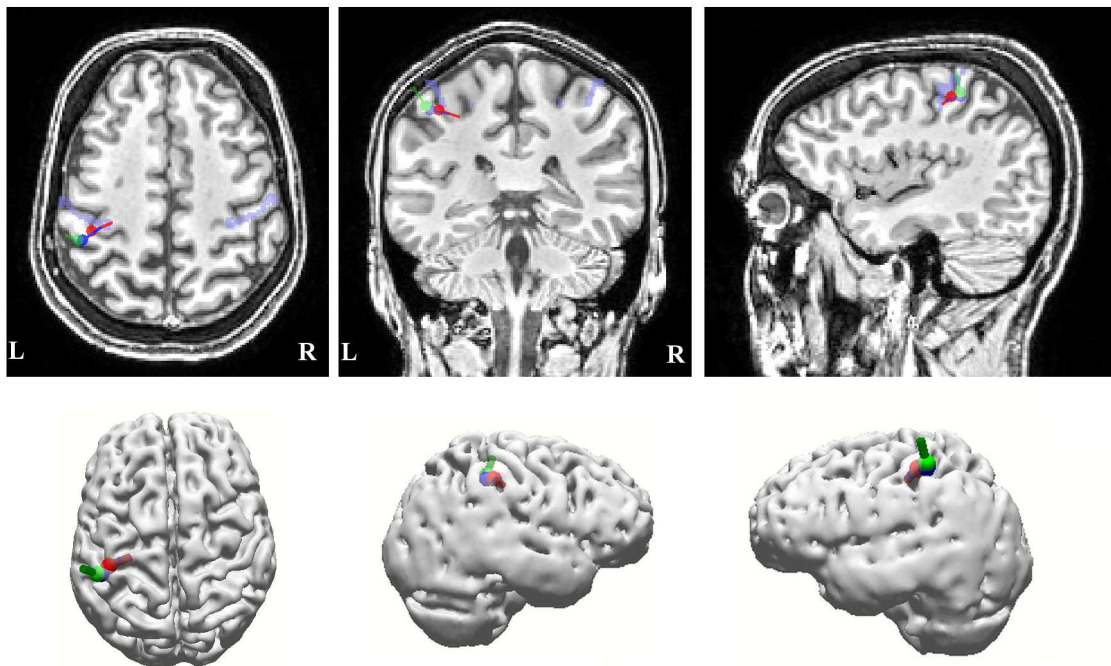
Source reconstructions for the N20(m) component for a healthy subject based on EEG (blue), MEG (no regularization) (green) and EMEG (red) shown on the MRI (upper figures) and on a volume rendering of the brain (lower figures). Left and right sides are depicted with L and R, respectively, in the top figures. The Broadmann 3 area is highlighted with purple in MRIs.
